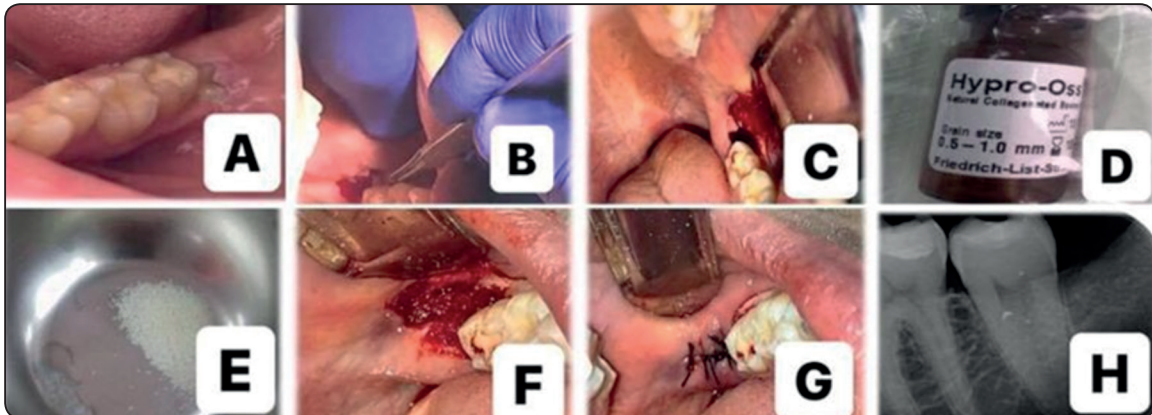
A. preoperative photograph B. flab incision C. Flap reflection and buccal bone guttering D &E. Hypro-Oss bone graft F. Hypro-Oss (HA) placement G. Suturing h. 2 months Postoperative radiograph
